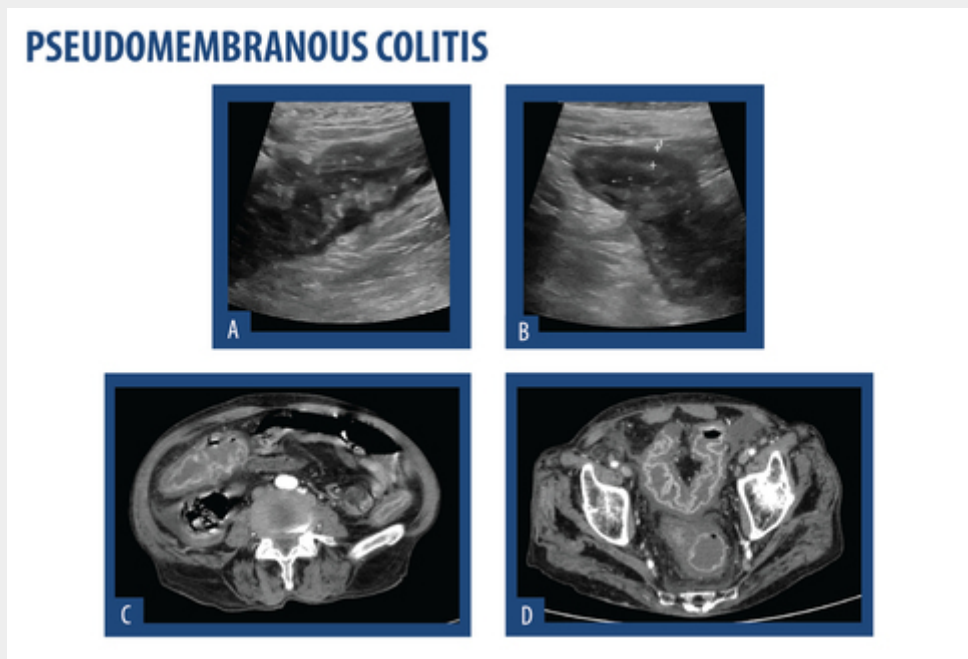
35 year old patient with recent diarrhea and presenting with acute RLQ pain. On US (A,B) there was marked thickening of bowel loops and some fluid within and surrounding the bowel. There was high suspicion for inflammatory bowel disease. The patient underwent CT (C,D) which demonstrated an irregular and "shaggy" wall thickening and enhancement of the luminal surface, indicating hyperemia.
